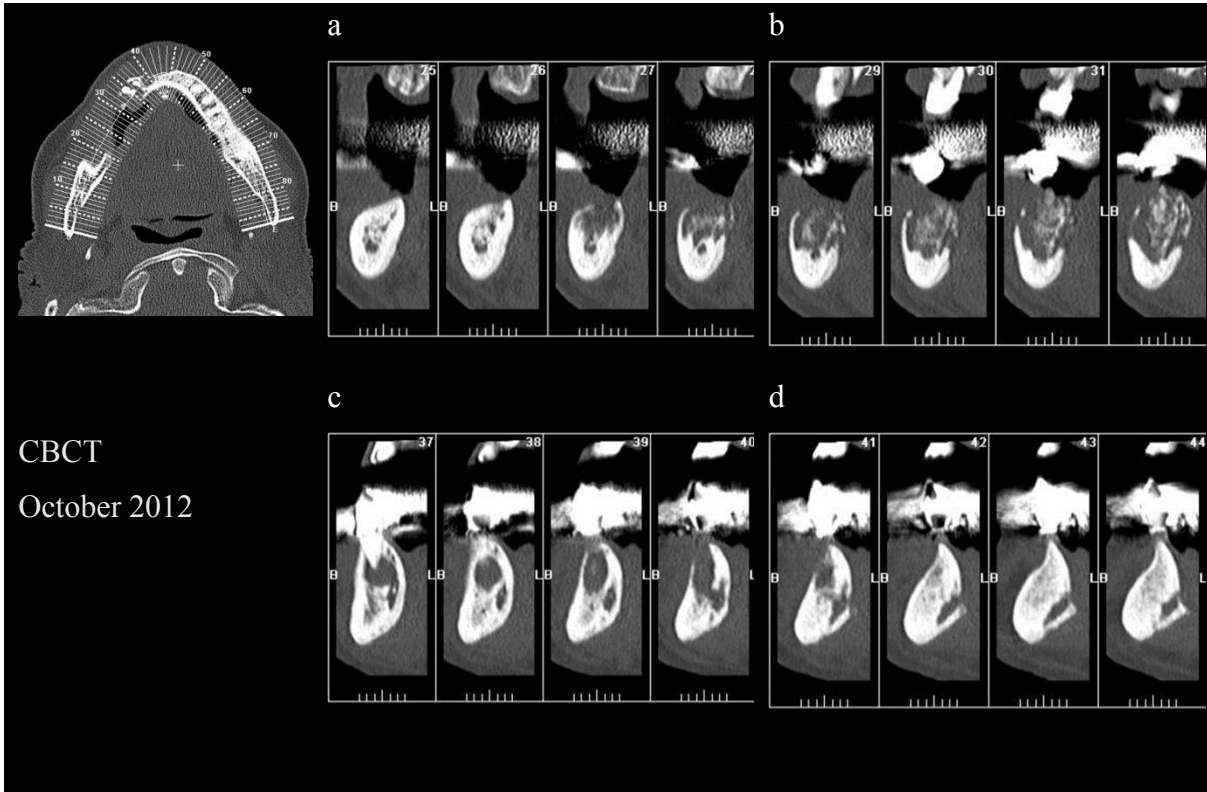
Cone Beam Computer Tomography. Upper line; a): molar area; b): premolar area. Bottom line; c/d): metal foramen.
